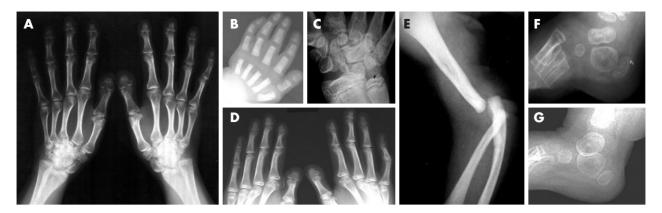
Radiographic features of Larsen syndrome. (A,B) Shortening and broadening of the distal phalanges, most notable in the thumb. Supernumerary carpal bones and a bifid calcaneal ossification centre are commonly observed. Individuals with an overlap of Larsen syndrome and atelosteogenesis type III show more severe skeletal malformations, such as a distally tapering humerus (E). (A) Case 15, (B,E,F) case 20 (aged 1 year), (C,D) case 20 (aged 14 years), (G) case 6.
